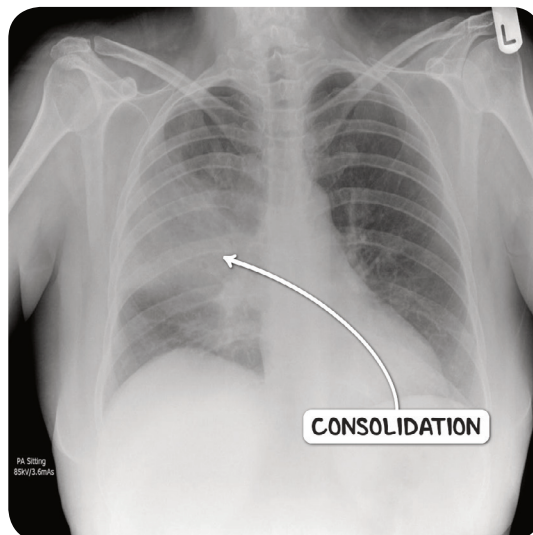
A plain chest radiograph demonstrating consolidation of the right middle lobe in an individual with lobar pneumonia.
